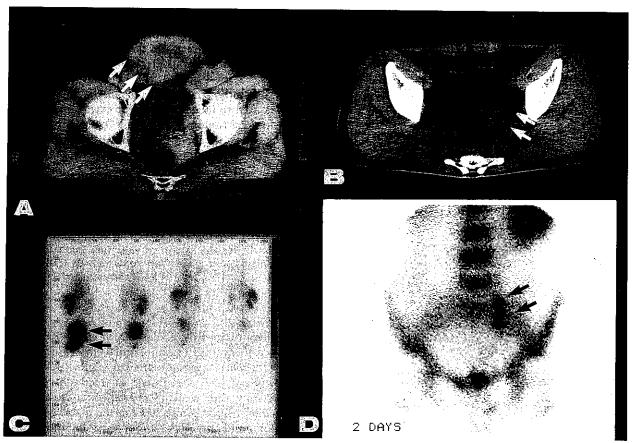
CT images (A, B) and whole-body scintigraphy of patients #5 (C) and #10 (D) with recurrent rectal cancer. Both anterior and posterior views gave a clear tumor image at day 1 in patient #5. In patient #10, an anterior spot view of the antibody scan shows an image of the tumor consistent with the CT image.
